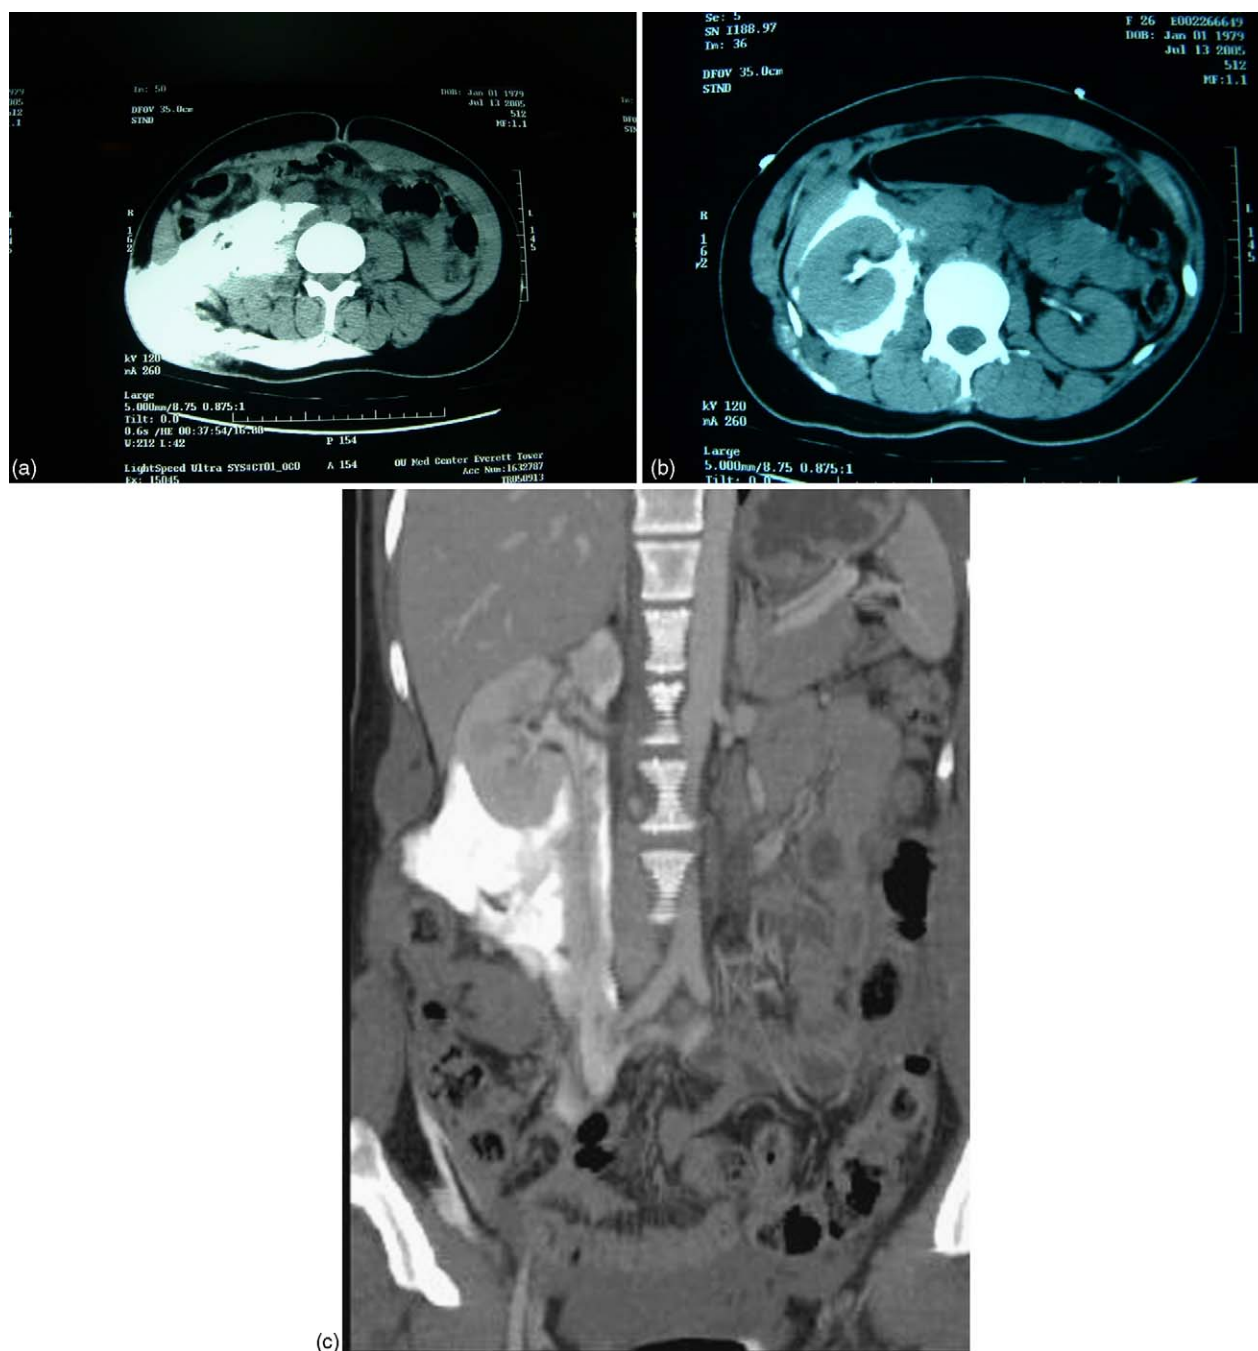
Computed tomography of abdomen and pelvis with delayed intravenous contrast. Transverse sections (a and b) and sagittal reconstruction (c).
